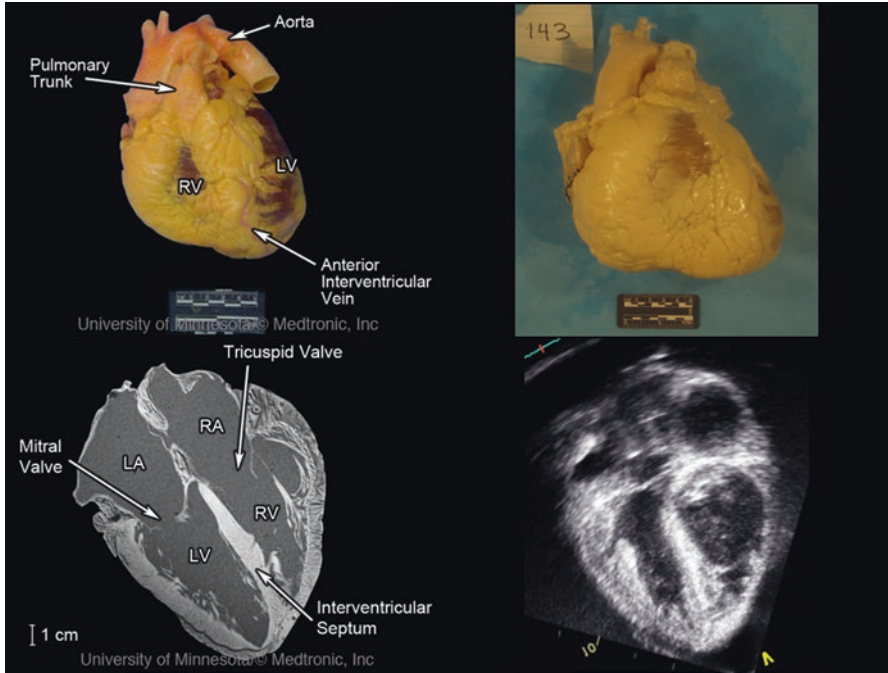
Images of a heart received by the Visible Heart® library and imaged fresh (upper left panel), after perfusion fixation (upper right panel) and scanned in a 3T Siemens MRI scanner (bottom left panel) and GE Vivid I ultrasound (lower right panel) in the four-chamber long-axis view. (Modified from the Atlas of Human Cardiac Anatomy [15])
